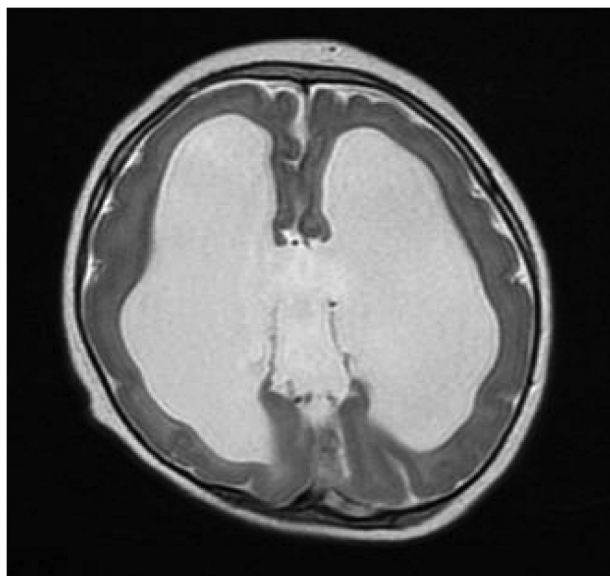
Axial brain MRI of a patient with ONH and cerebral dysplasia as well as ventricular enlargement (Number 2).
